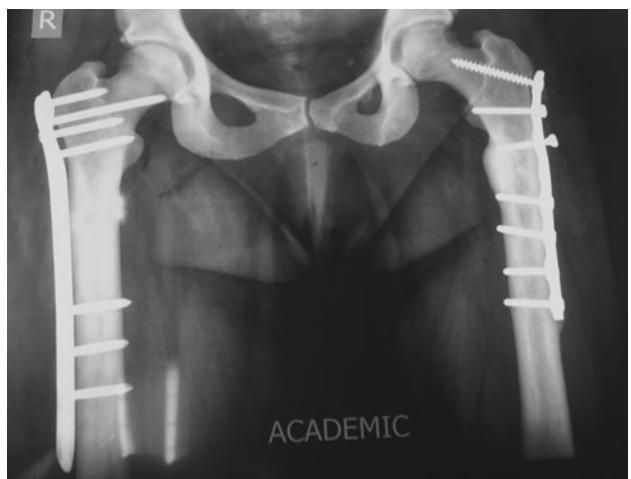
22-week postoperative X-ray showing union.
